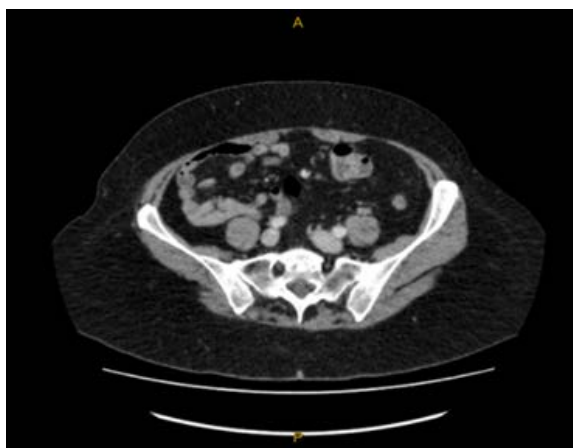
Right (Axial View): Axial CT image further supports the diagnosis of malrotation, showing the duodenum failing to cross the midline, and mesenteric vessels appearing in an atypical orientation. There is no radiological evidence of a whirl sign or bowel ischemia, ruling out acute midgut volvulus.
